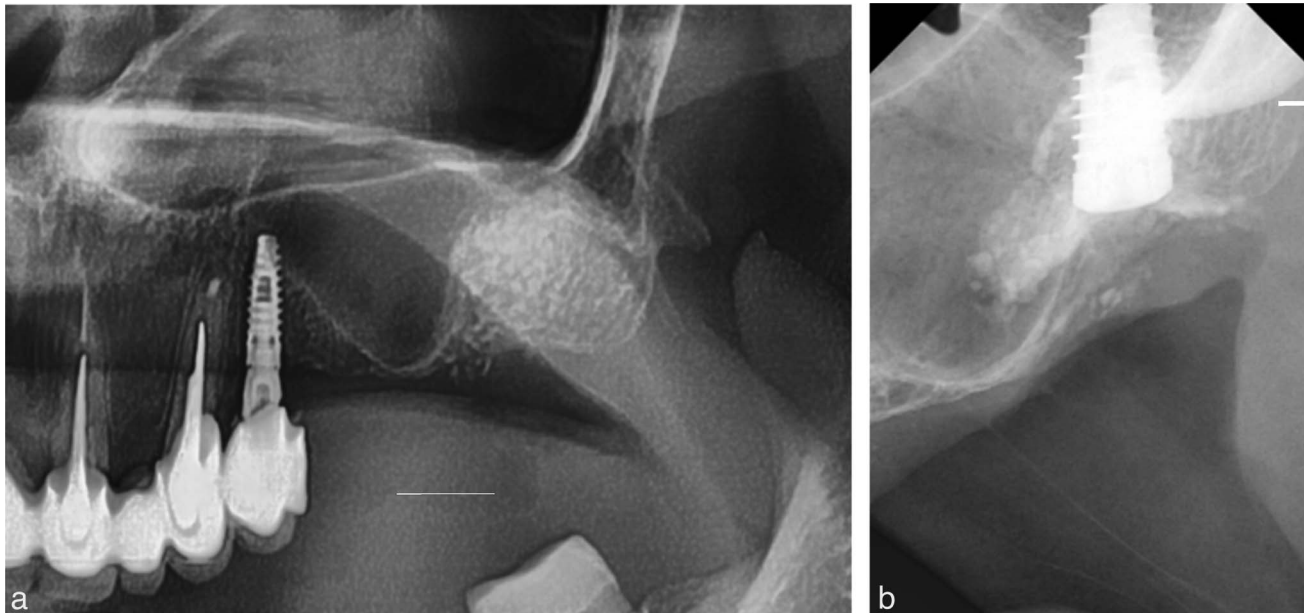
Radiograph following 8 months postgraft healing (a) and following implant placement (b).
